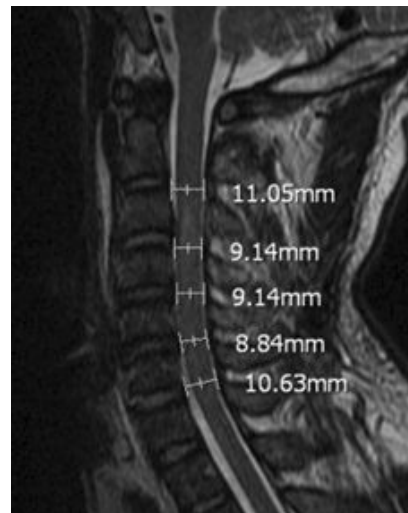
MRI 正中矢状面上测量 C₂-C₇ 各椎间盘层面椎管矢状径
